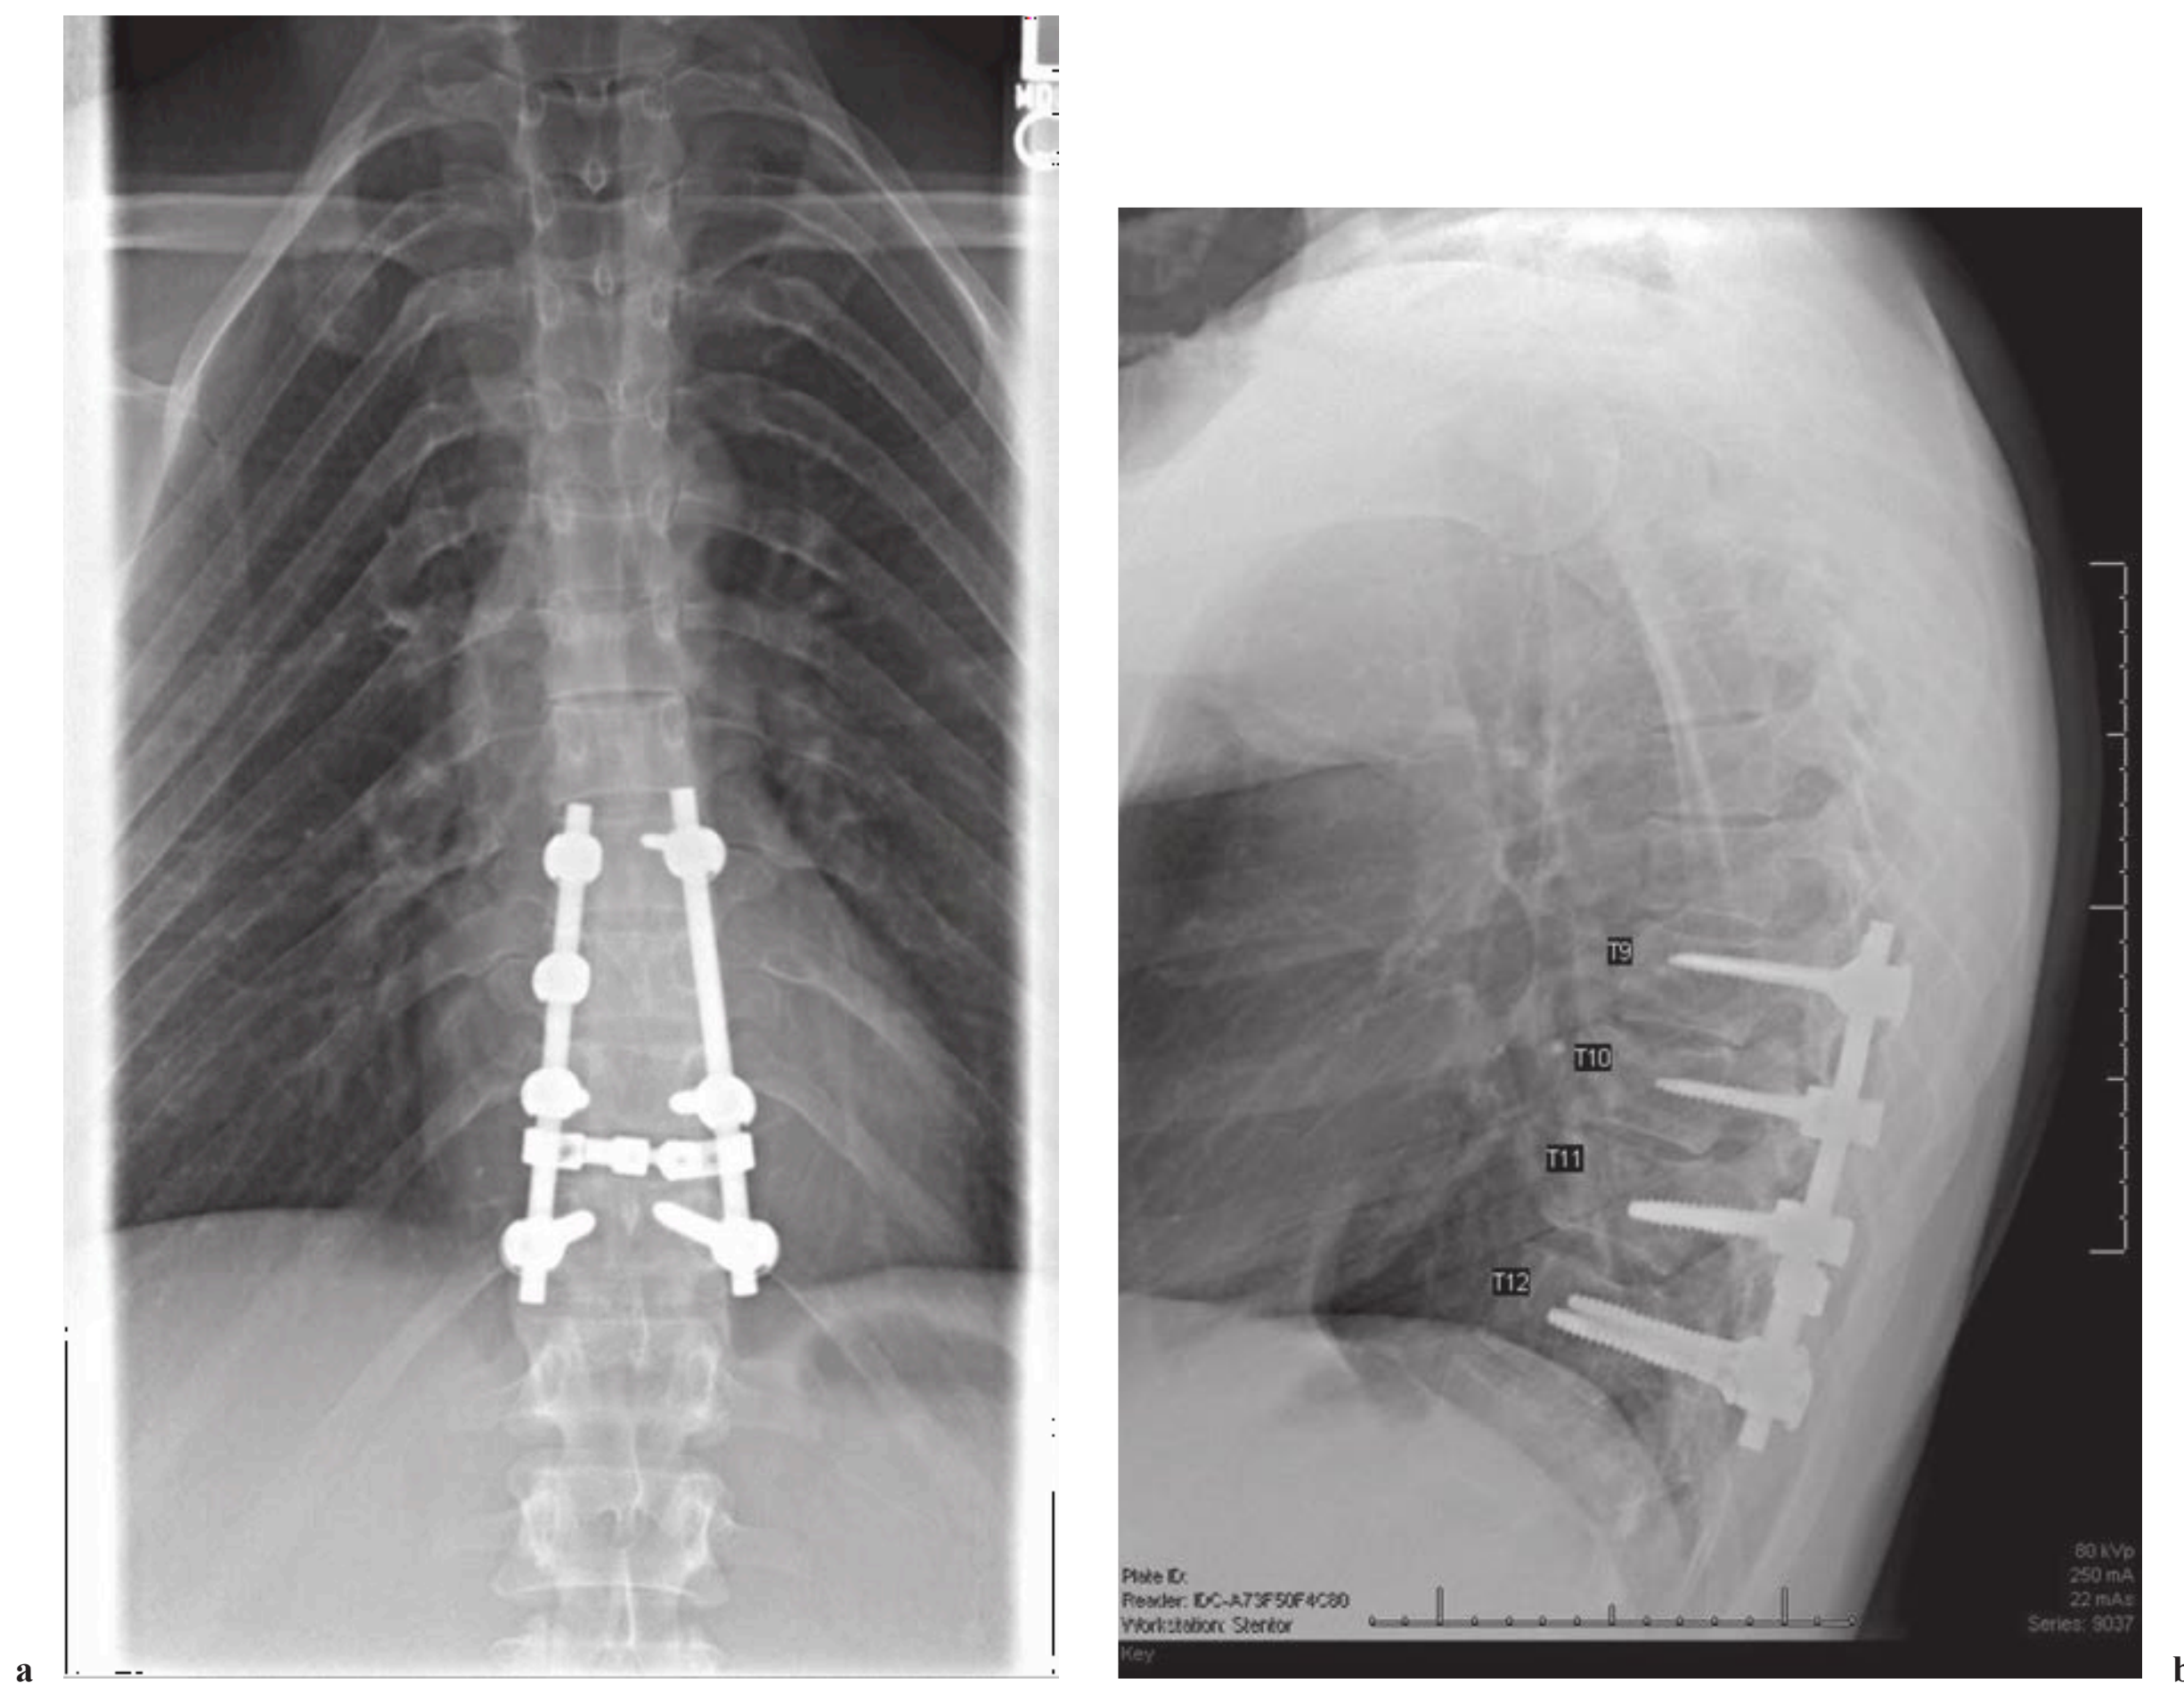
Postoperative (a) AP and (b) lateral radiographs of the patient depicted in Figs. 15.1 and 15.2 underwent open reduction and T9 to T12 arthrodesis instrumentation using pedicle screws, rods, and a cross connector with in situ autograft, cancellous allograft 90 mL, and demineralized bone matrix 20 mL. He was fully recovered at his 1-year postoperative visit.
